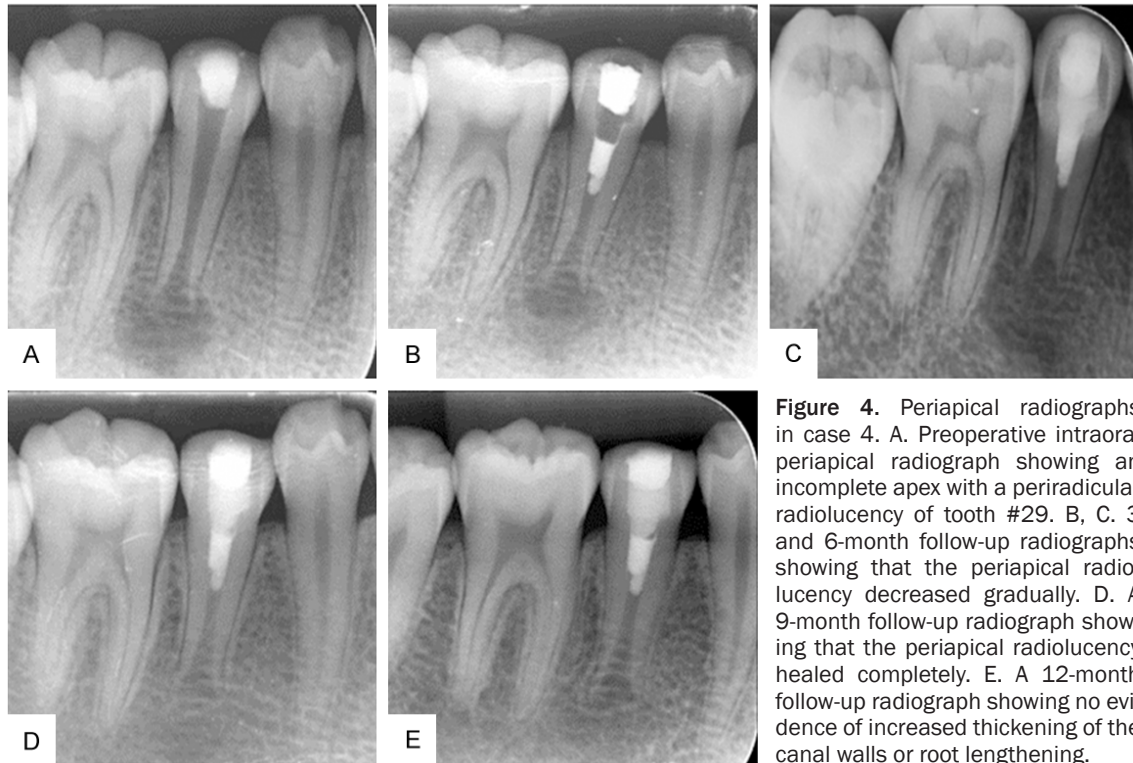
Periapical radiographs in case 4. A. Preoperative intraoral periapical radiograph showing an incomplete apex with a periradicular radiolucency of tooth #29. B, C. 3 and 6-month follow-up radiographs showing that the periapical radiolucency decreased gradually. D. A 9-month follow-up radiograph showing that the periapical radiolucency healed completely. E. A 12-month follow-up radiograph showing no evidence of increased thickening of the canal walls or root lengthening.
